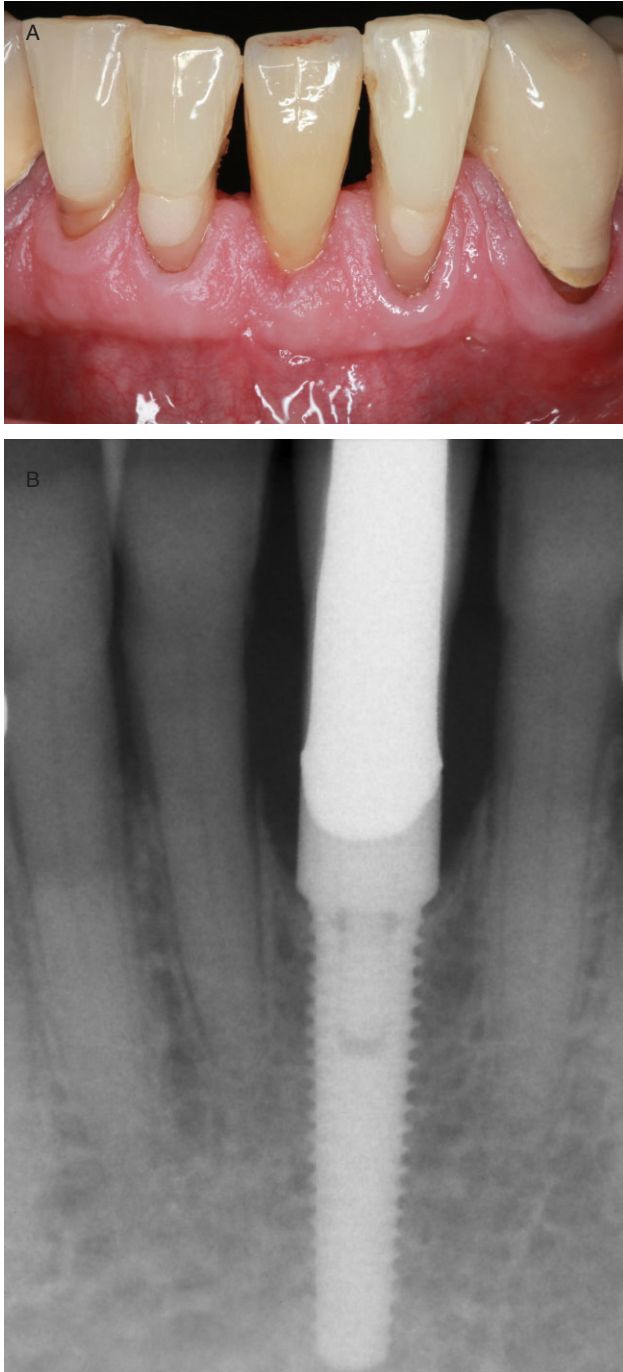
Single-tooth replacement in the mandible. (A) Clinical aspect 68 months after extraction and simultaneous implant placement. The PES rating is 11. The marginal contour is reestablished. Width and thickness of attached mucosa are improved. (B) Intraoral radiograph obtained 68 months after surgery. A marginal bone level slightly coronal to the first thread is apparent. (PES = pink esthetic score.)
